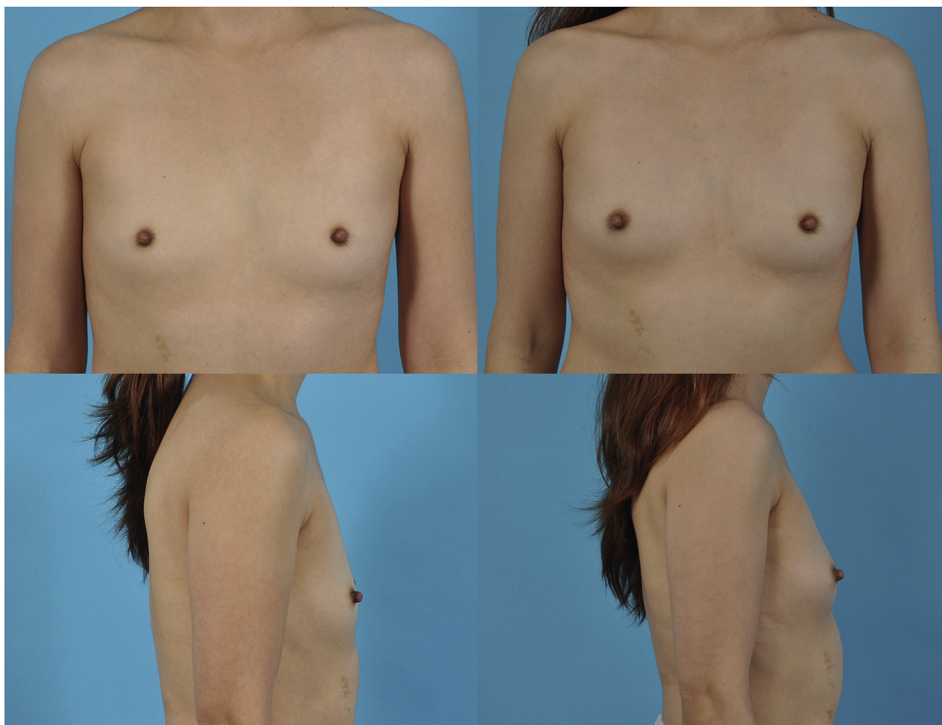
A 39-year-old woman before (left) and after (right) 12 weeks of EVERA use. Dynamic contrast-enhanced magnetic resonance imaging showed no significant difference in breast density before and after the application of the expansion device.
